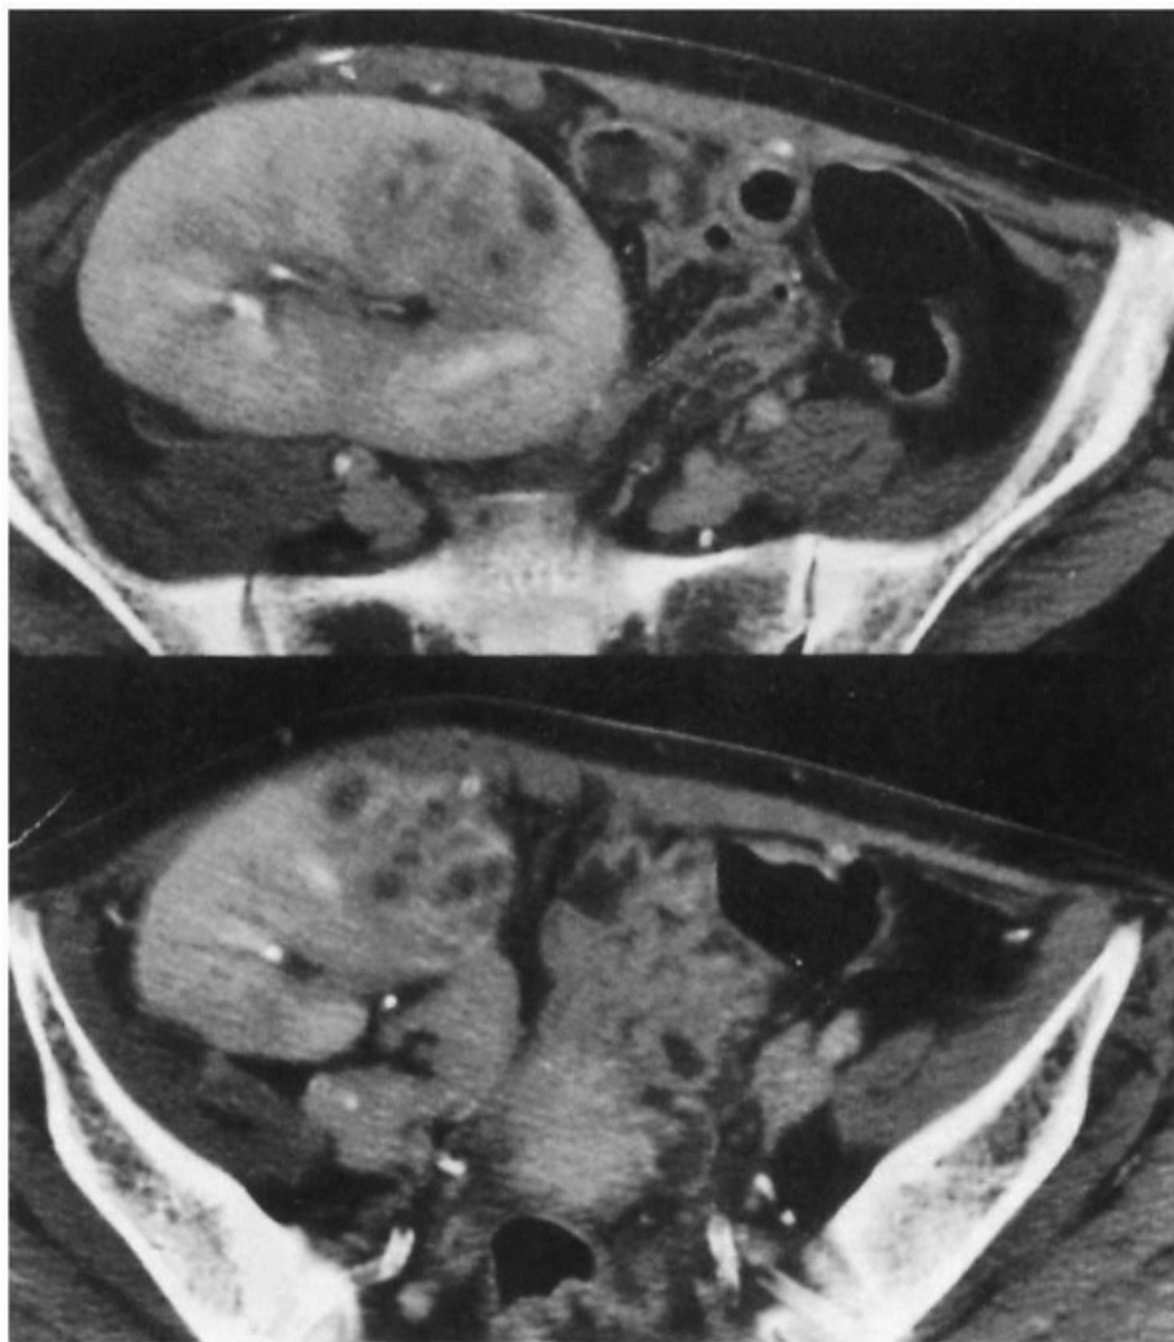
Abscess in a renal allograft. There is a heterogeneous mass on contrast-enhanced computed tomography. Many small compartments preclude percutaneous drainage. Renal function was surprisingly well preserved. Abscess resolved after intensive antibiotic therapy.
